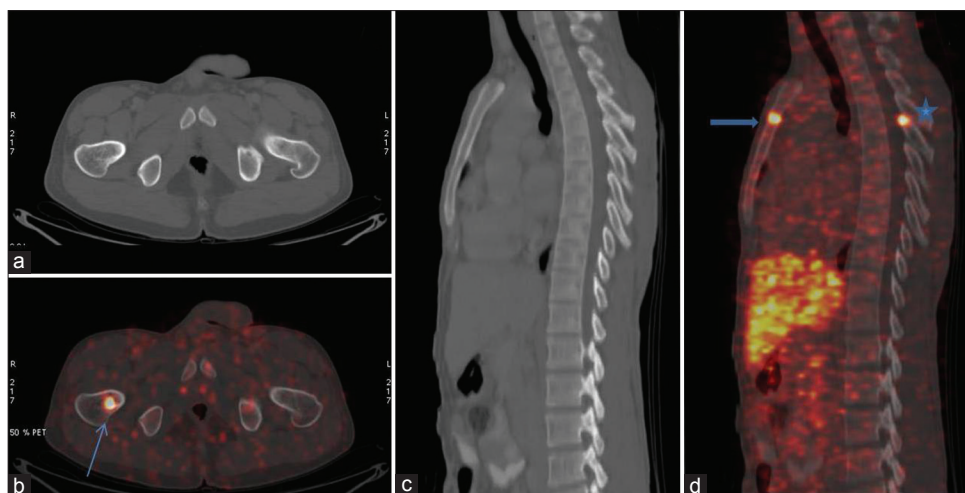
A 16-year-old boy diagnosed with pheochromocytoma underwent ⁶⁸Ga-DOTATATE positron emission tomography/computed tomography (CT). Intense ⁶⁸Ga-DOTATATE avid focus is noted in right femur (arrow) with no definite changes on CT. In the right hand panel foci of Ga68 avidity are seen in sternum (arrow head) and D6 vertebral posterior elements*, again with no definite changes on CT images (c) On follow-up confirmed to be skeletal metastases
